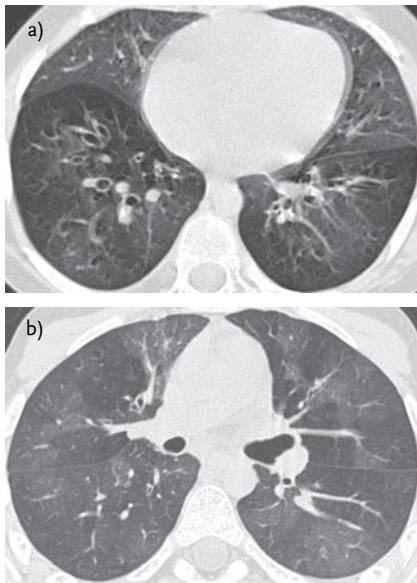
a) HRCT scan of a 4-year-old boy with bronchiolitis obliterans following Mycoplasma pneumoniae infection. Bilateral areas of increased and decreased parenchymal attenuation (mosaic perfusion), bronchiectasis and air-trapping can be seen. b) Bronchiolitis obliterans in a 13-year-old boy 2 years after bone marrow transplantation for acute lymphoblastic leukaemia. The HRCT scan shows a bilateral mosaic perfusion pattern, air-trapping and bronchial dilatation.
